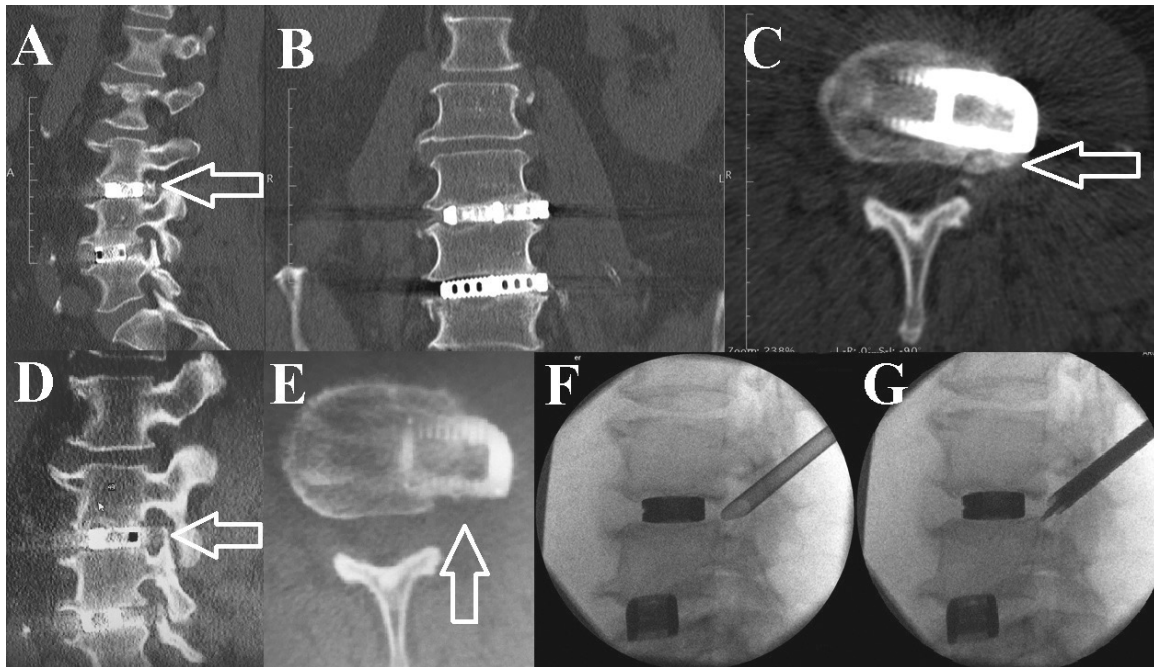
Endplate fracture. (A) Sagittal CT reconstruction demonstrating the bone fragment (open arrow) in the left L3-4 foramen after the L3-4 and L4-5 standalone LLIF. (B) Coronal CT reconstruction demonstrating the L3-4 (cage slightly eccentric to the left) and L4-5 LLIFs. (C) Axial CT image through the L3-4 disc space after the L3-4 LLIF (open arrow indicates the endplate fracture). (D) Sagittal CT reconstruction demonstrating the patent left L3-4 foramen after endoscopic decompression. (E) Axial CT image through the L3-4 disc space after endoscopic decompression (open arrow indicates the removal of the endplate fracture). (F) Lateral fluoroscopic view of the beveled 7-mm tubular retractor positioned in the L3-4 foramen. (G) Lateral fluoroscopic view of the endoscopic grasper positioned in the L3-4 foramen.
